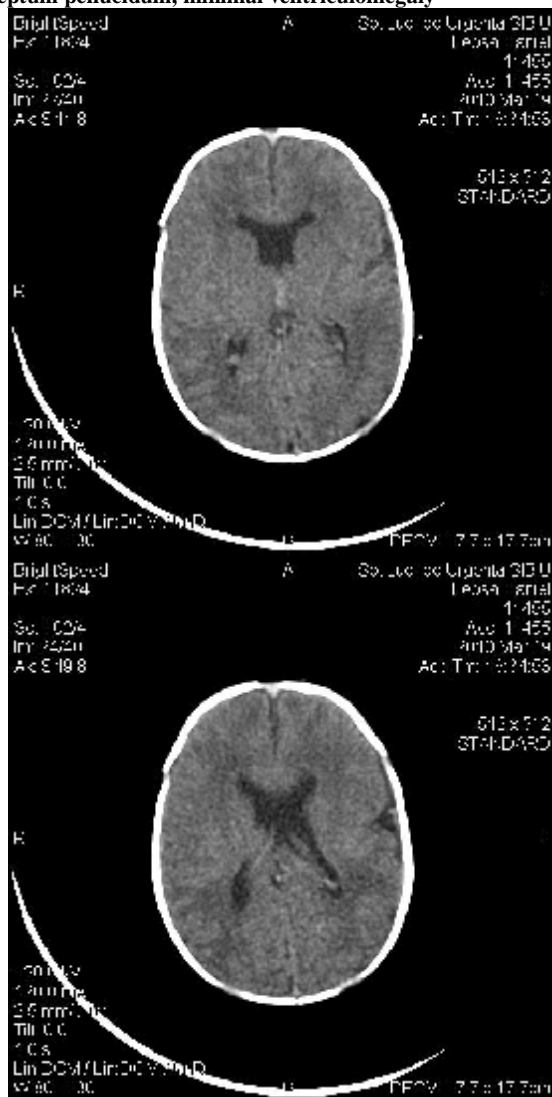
Cranial CT – right sided parietal cleft, absent septum pellucidum, minimal ventriculomegaly
